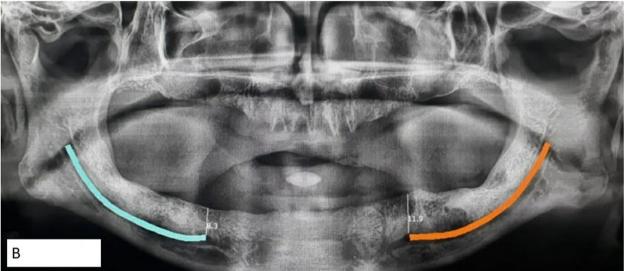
Measurement of Mental loop A) PR view, B) CBCT.
